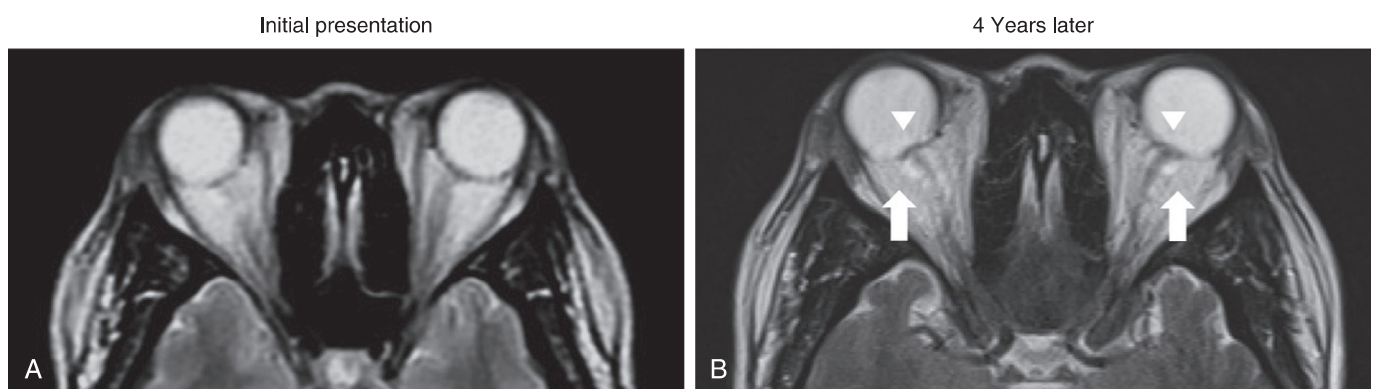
Longitudinal evolution of magnetic resonance imaging findings of idiopathic intracranial hypertension. (A) A T2-weighted axial image of a middle-aged female patient reveals normal-appearing globes and optic nerves. (B) The patient presented with worsening symptoms 4 years later and developed optic nerve sheath distension (*arrows*) as well as optic nerve head protrusion (*arrowheads*). *Continued*
